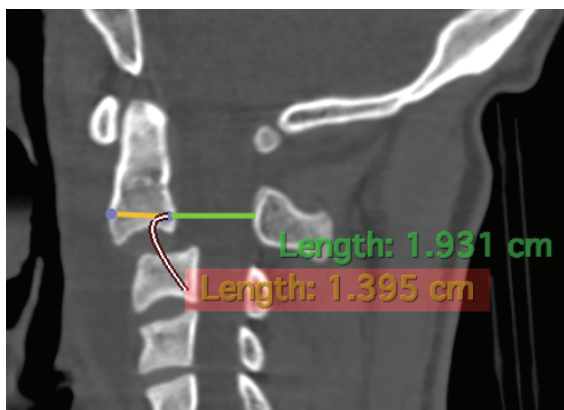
Measurement of the Torg-Pavlov Ratio or canal to body ratio of the C2 sagittal view in CT Scan showing the result is 1.38. If the score is <0.8 indication of cervical stenosis and the normal value is 1.0.
